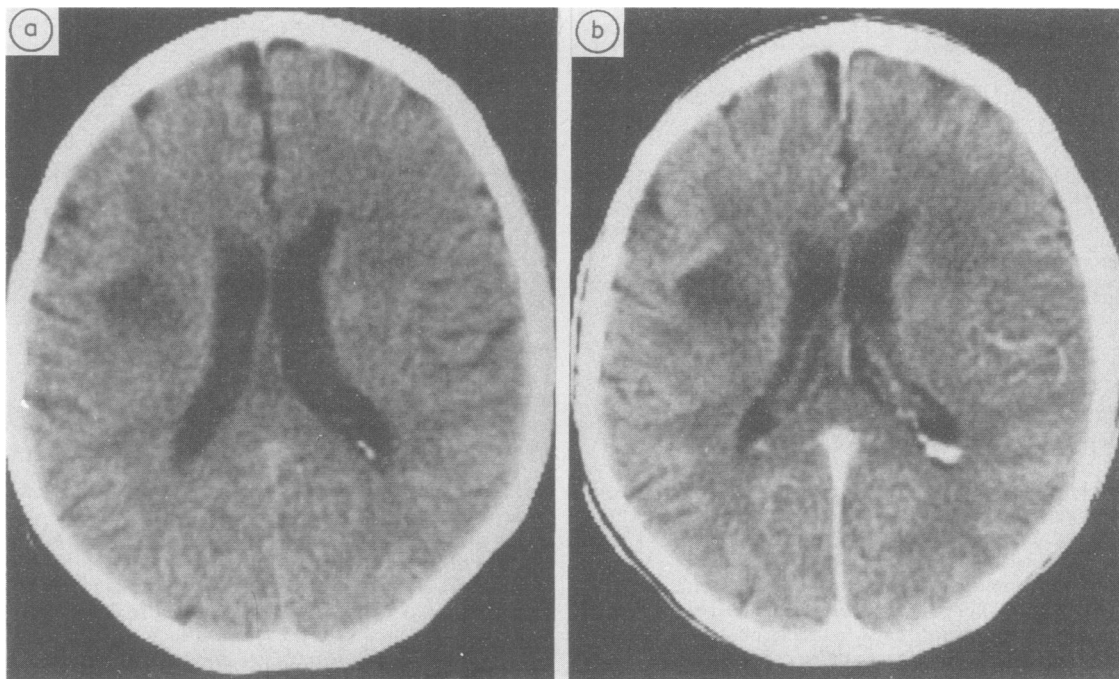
CT brain scan of patient one (1) unenhanced, (2) contrast enhanced.
